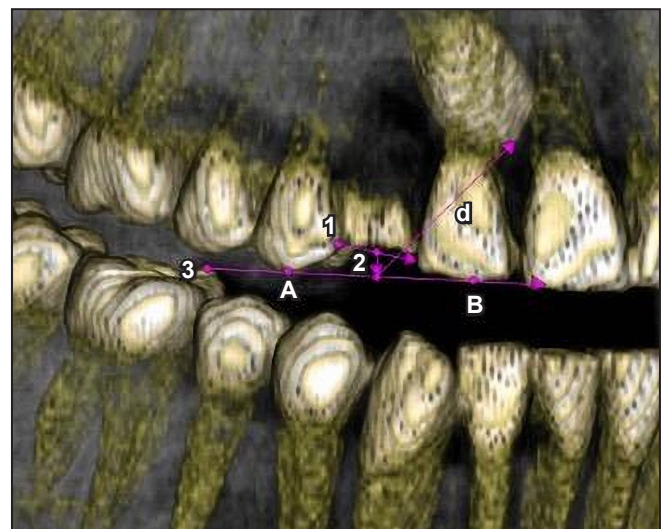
Evaluation of actual eruption path length (d) on three-dimensional CBCT.
